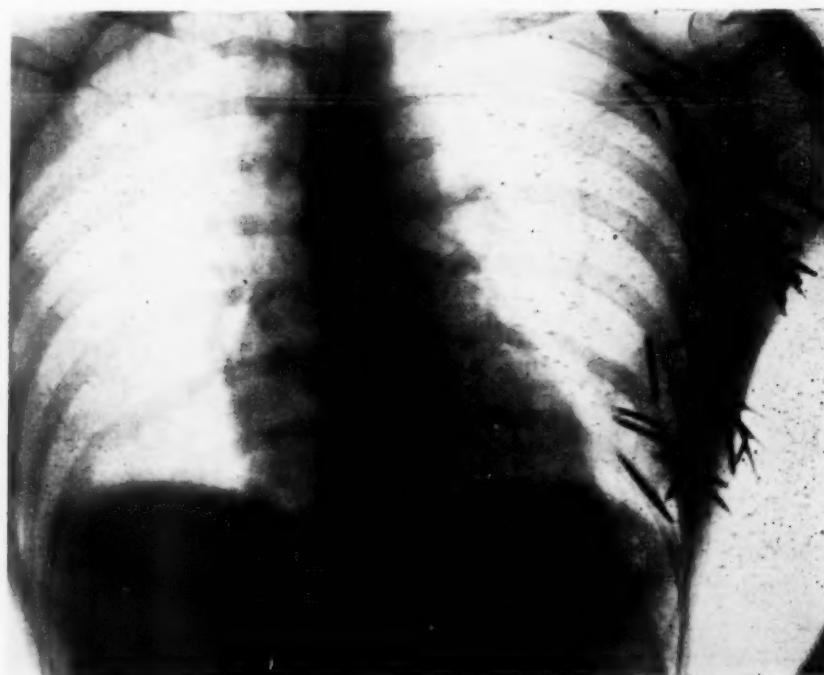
Roentgenogram of the same case, showing the needles imbedded in the tissues.
